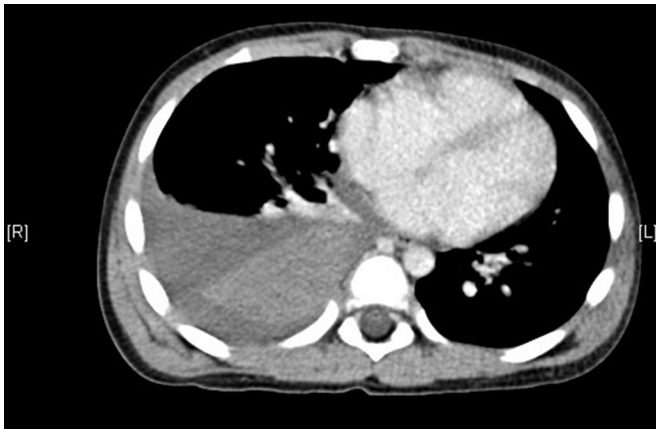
A contrast-enhanced computed tomography scan showed a solitary triangular mass without enhancement, and massive pleural effusion in the right pleural cavity.
